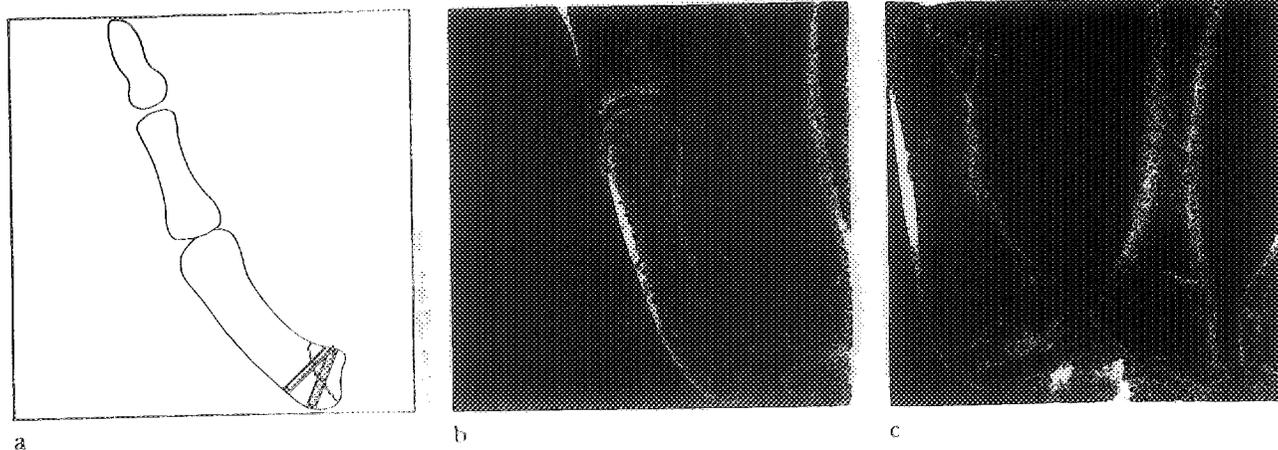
Fixation of Bennett's fracture (a). Radiograph of a displaced Bennett's fracture seen on admission (b) and as healed six months after fixation with two 2 by 25 mm BIOFIX® rods (c).
